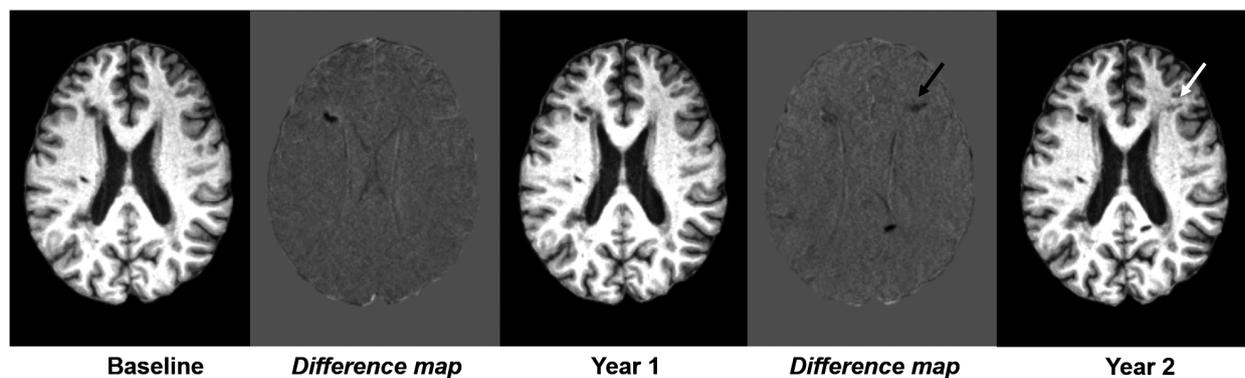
Identification of new lacunes. T1-weighted images at each time-point were coregistered to the Montreal Neurological Institute template and bias corrected. This allowed creation of difference maps to identify new areas of signal change. In each new area, reference was made to original T1-weighted images, and to other available sequences to confirm if it was a new lacune. The arrow highlights an area of signal change, which represented new white matter hyperintensity and a perivascular space. One new lacune can be seen on each difference map as a black area.
